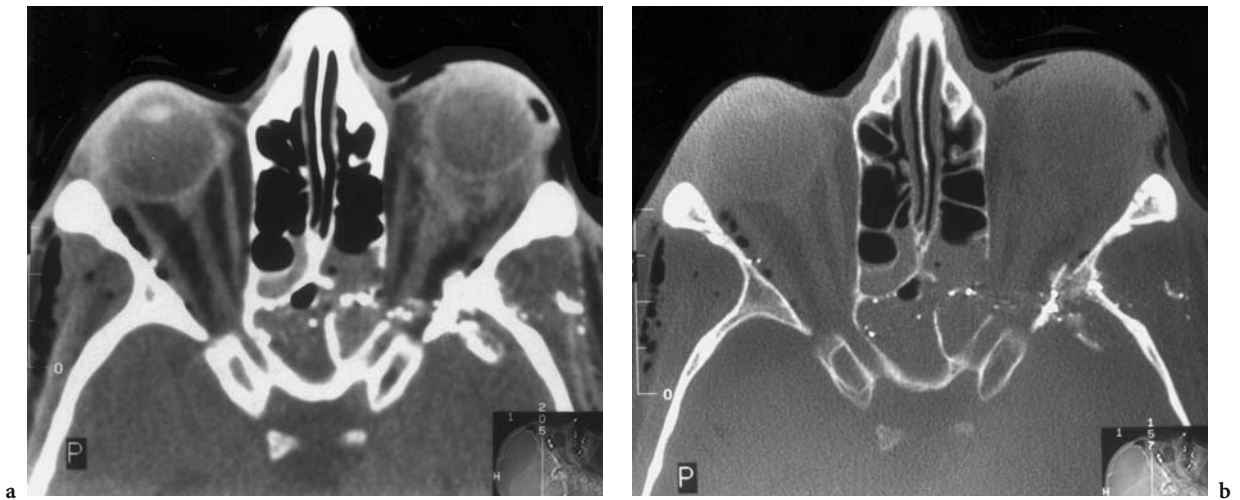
A 33-year-old man with bullet injury after suicide attempt. Diagnosis: rupture of the left optic nerve. CT: a axial view at the level of the optic nerve showing rupture of the optic nerve in the left orbital apex, bullet and bone fragments, as well as destruction of the lateral and medial orbital wall. Note the deformed globe, which ruptured as a result of the sudden, great pressure enhancement produced by the shot. The irregular hyperdensities of the retrobulbar space correspond to the presence of an additional retrobulbar hematoma. b Corresponding bone window with distinct differentiation of the different fragment materials. Note additional air bubbles in the right orbit and temporal fossa
